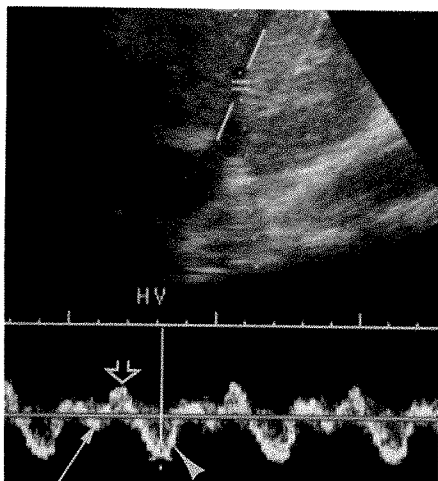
Hepatic vein duplex Doppler sonogram in tricuspid regurgitation shows a systolic wave (solid arrow) that is antegrade but very small (10 cm/sec); diastolic wave (arrowhead) is much larger (32 cm/sec). Note that v wave (open arrow) is now large (26 cm/sec).
